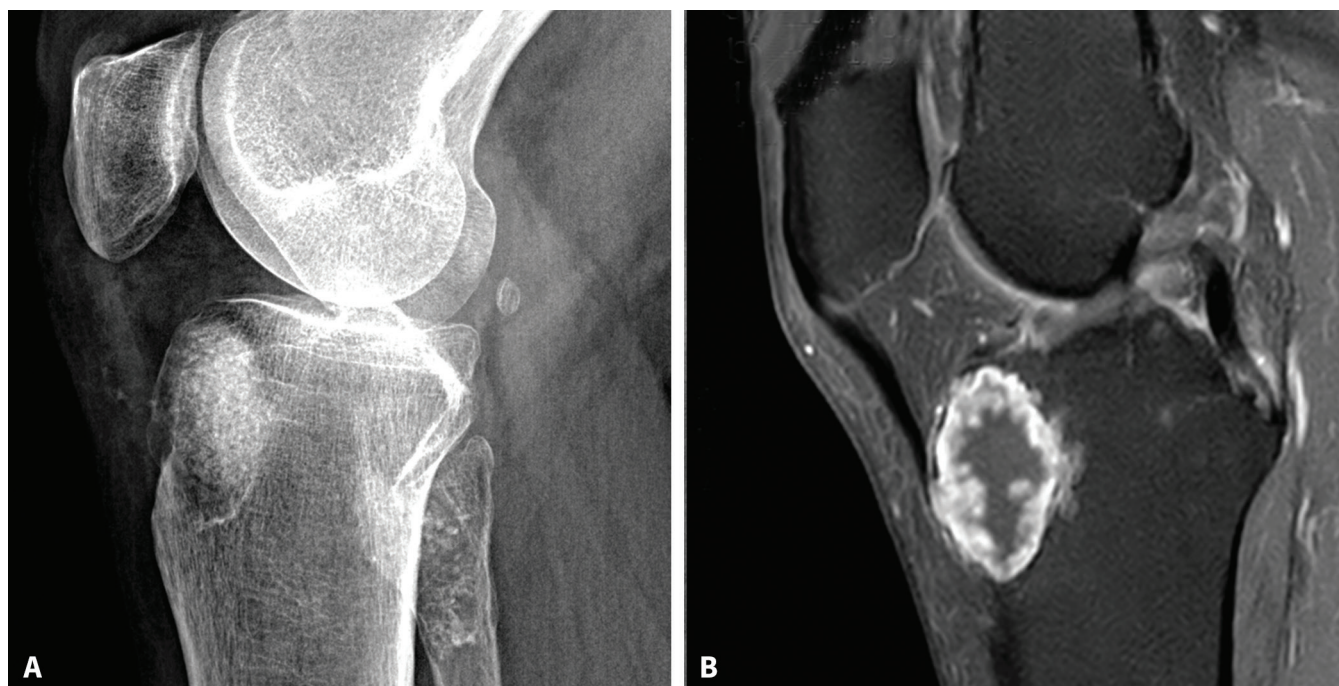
Radiographic (A) and MRI (B) images of a painful atypical cartilaginous tumour in the proximal tibia; on the right lower side of the radiographic image, there is also an asymptomatic enchondroma of the proximal tibia.
